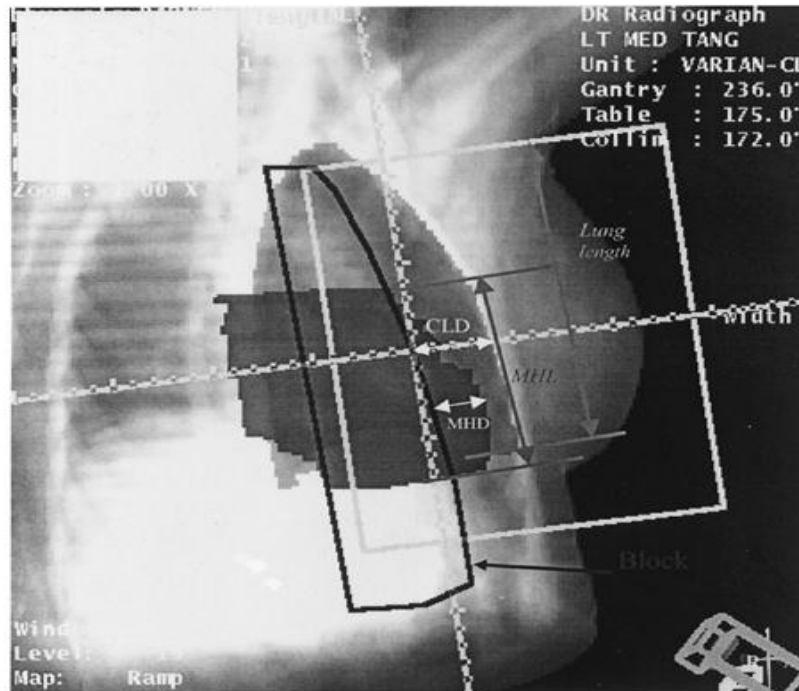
Computerised radiograph showing medial tangential view of a whole breast radiotherapy plan with the various parameters of plan evaluation such as CLD (central lung distance) and MHD (maximum heart distance) marked.
